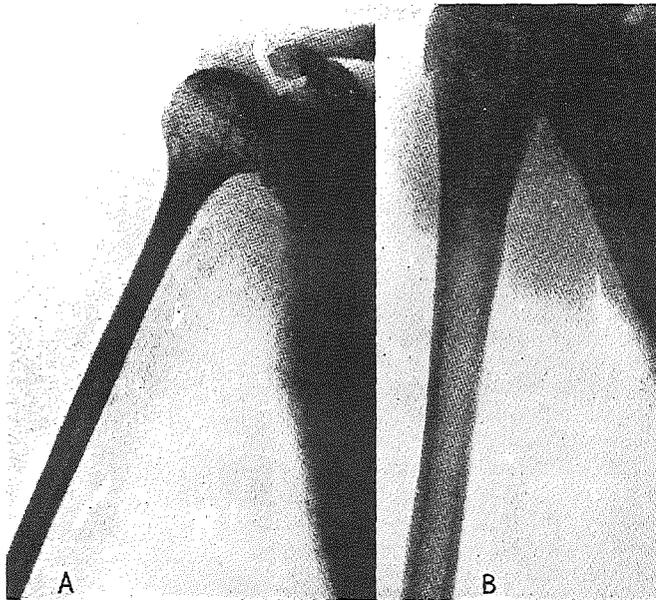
X-ray A is of an Italian boy in America, aged sixteen, with muscular dystrophy and external concentric osseous atrophy (see text, below). X-ray B is of a normal boy of the same age.
